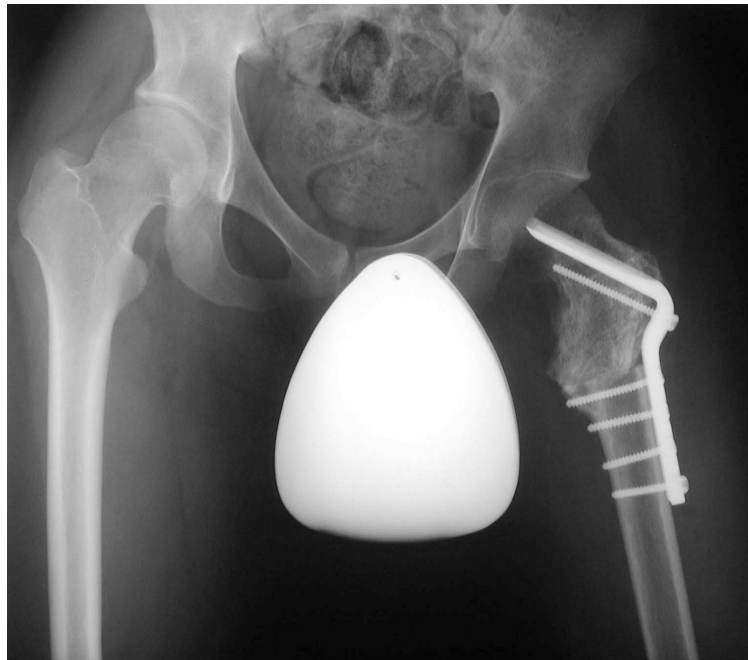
Plain radiograph after surgery showing morphology of 140 degrees.
